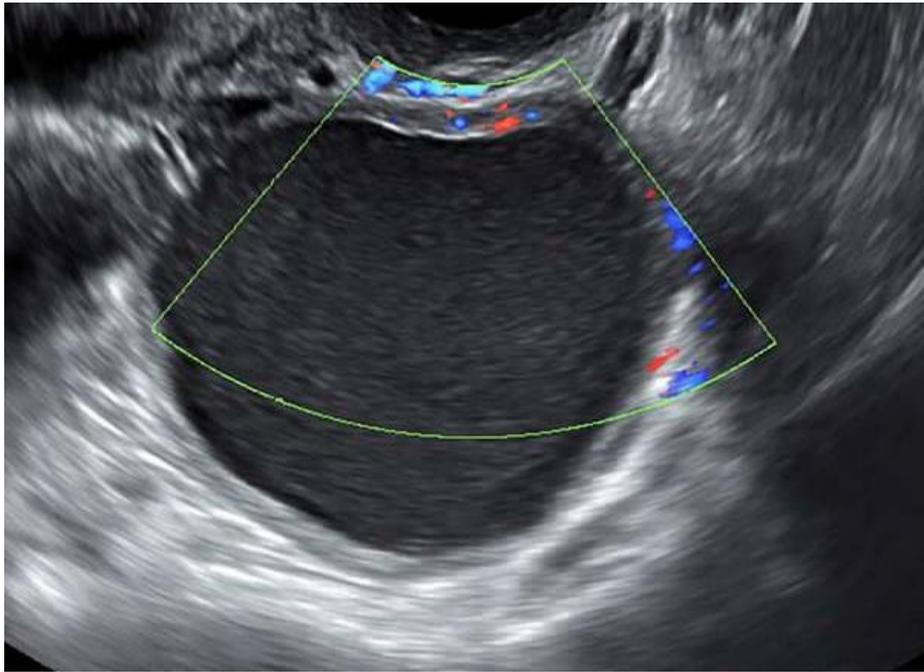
Patient, 21 years old. On the sonogram in the projection of the left ovary, a hypoechoic formation with even clear contours is visualized, 12x10 cm in size, with slight vascularization along the periphery in the color flow mode
